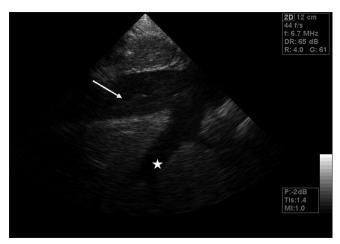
Transesophageal echocardiography left ventricular two-chamber view showing 22 mm pericardial effusion (arrow)
